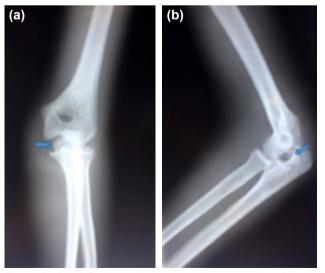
(a, b) Radiographs show an incarcerated medial epicondyle in the elbow joint (blue arrows), with valgus instability.
